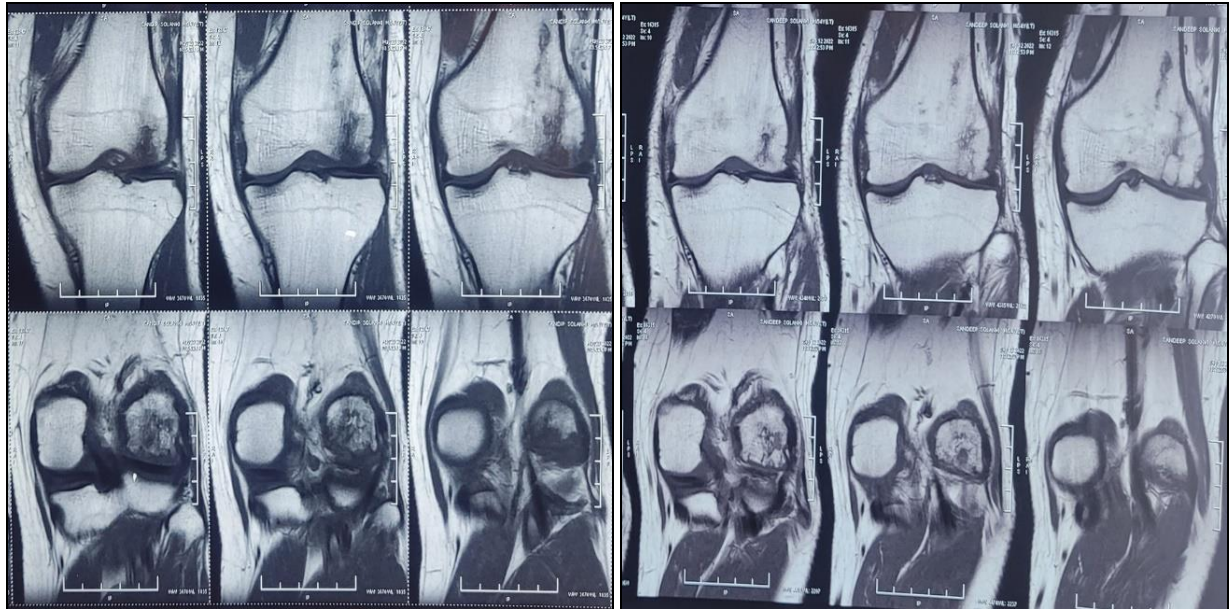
a, b: Image on the left (4a) shows coronal section T1 weighted MRI of the lateral femoral condyle preoperatively. Image on the right (4b) shows post operative changes in the corresponding areas.
